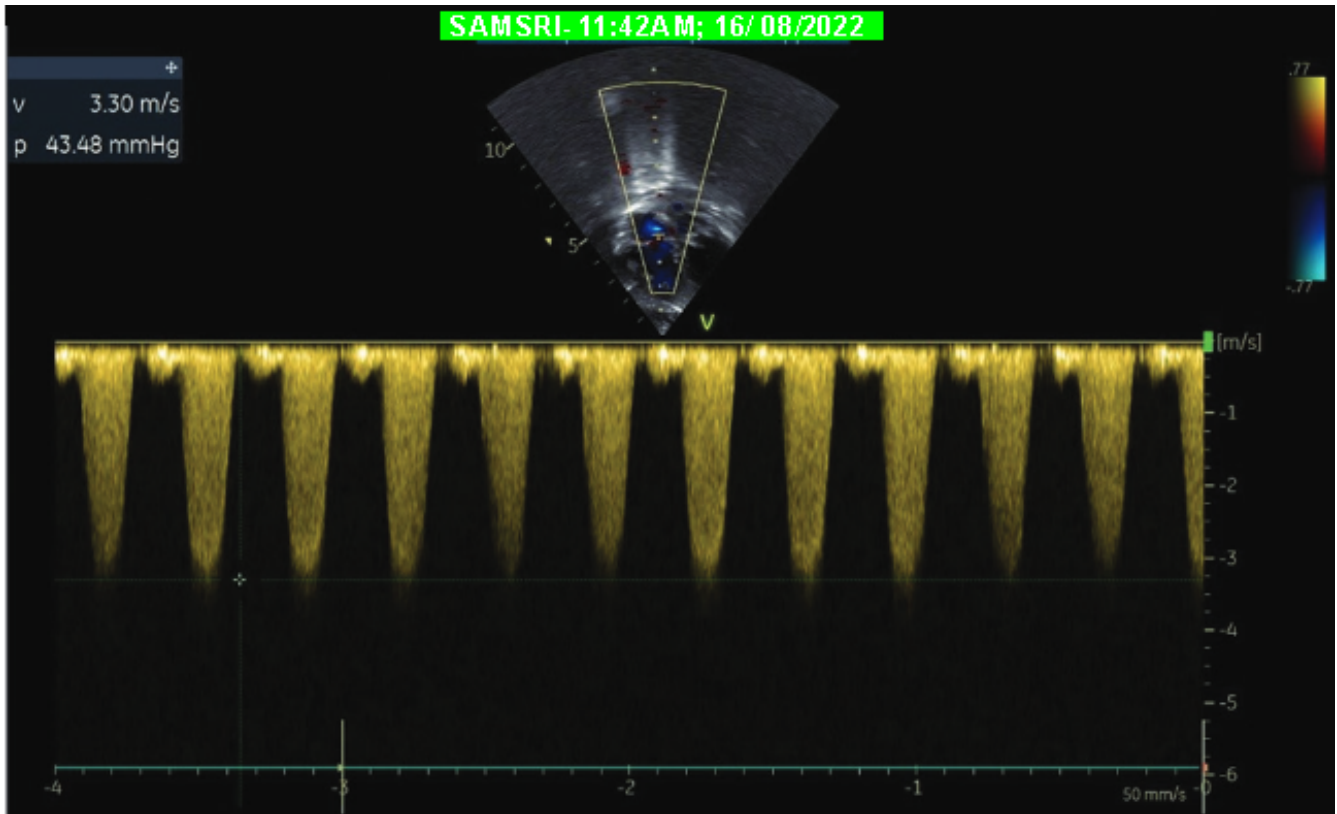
Postoperative transthoracic echo showing TR jet velocity
